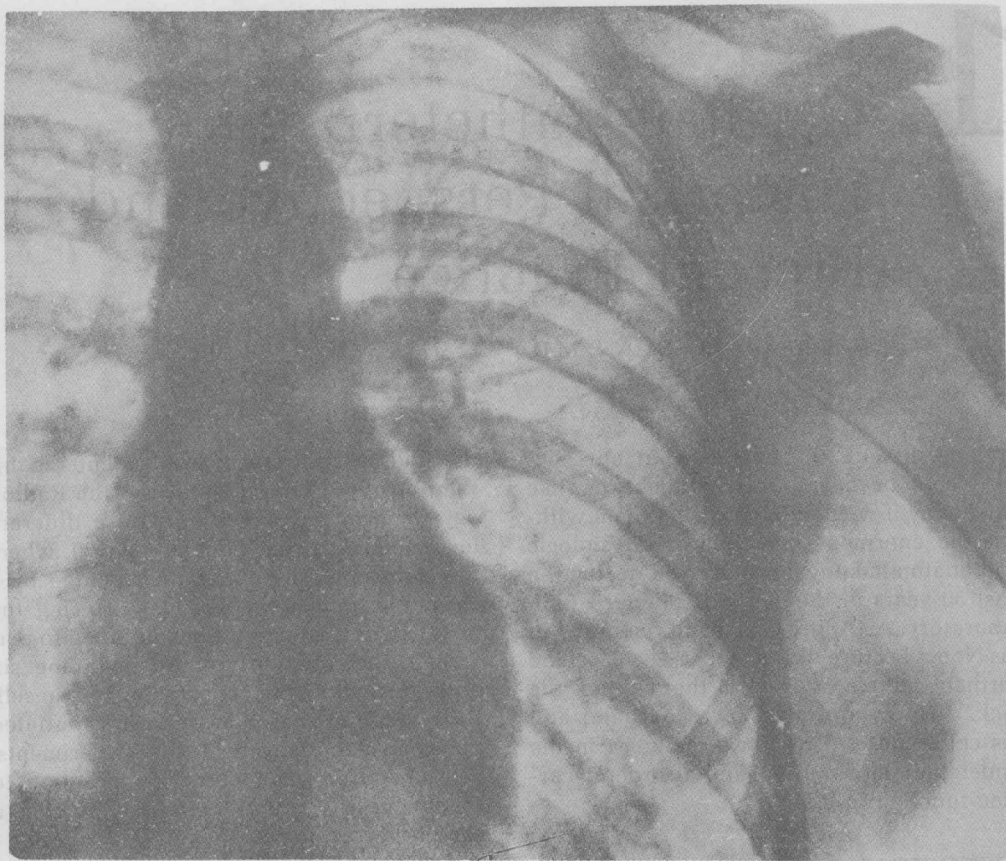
The first documented cardiac catheterization. At age 25, while receiving clinical instruction in surgery at Eberswalde, Werner Forssmann passed a catheter 65 mm through one of his left antecubital veins until its tip entered the right atrium. He then walked to the Radiology Department, where this x-ray was taken.² (Klin Wschr 8:2085, 1929. © Springer-Verlag Berlin, Heidelberg, New York)
